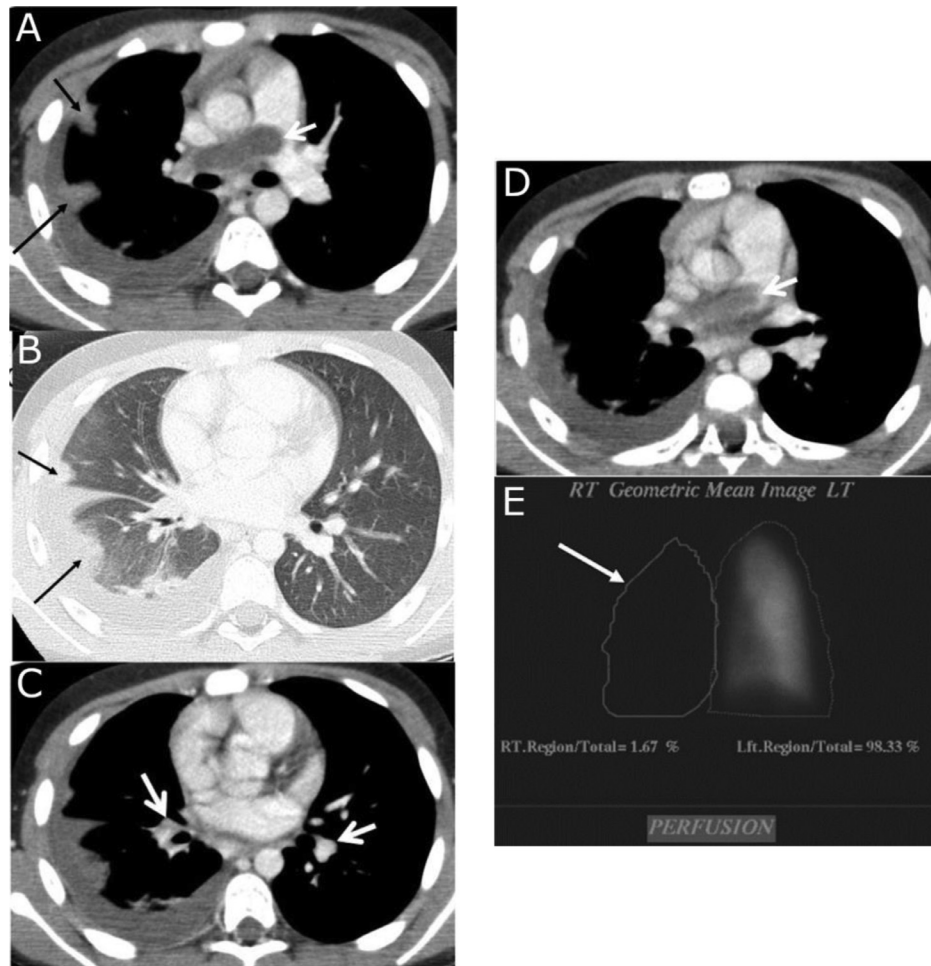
Preoperative image findings. (A) CTA with soft tissue window showing a large non-enhancing filling defect in the right pulmonary artery (white open arrow). Peripheral wedge shaped pulmonary opacities suggesting developing infarcts (black solid arrows). There is associated reactive pleural effusion. (B) CTA with lung window showing wedge shaped pulmonary infarcts. (C) CTA with soft tissue window showing non-enhancing filling defect in the interlobar pulmonary artery on the right (white arrow on the right) and no filling defects on the left (white arrow on the left). (D) CTA with soft tissue window showing non-enhancing filling defect in the right pulmonary artery leading to mild expansion of the RPA with mild extension into the main pulmonary artery. There is normal opacification of the rest of the main pulmonary artery. (E) 99mTc-MAA scan showing lack of perfusion to the right lung.
